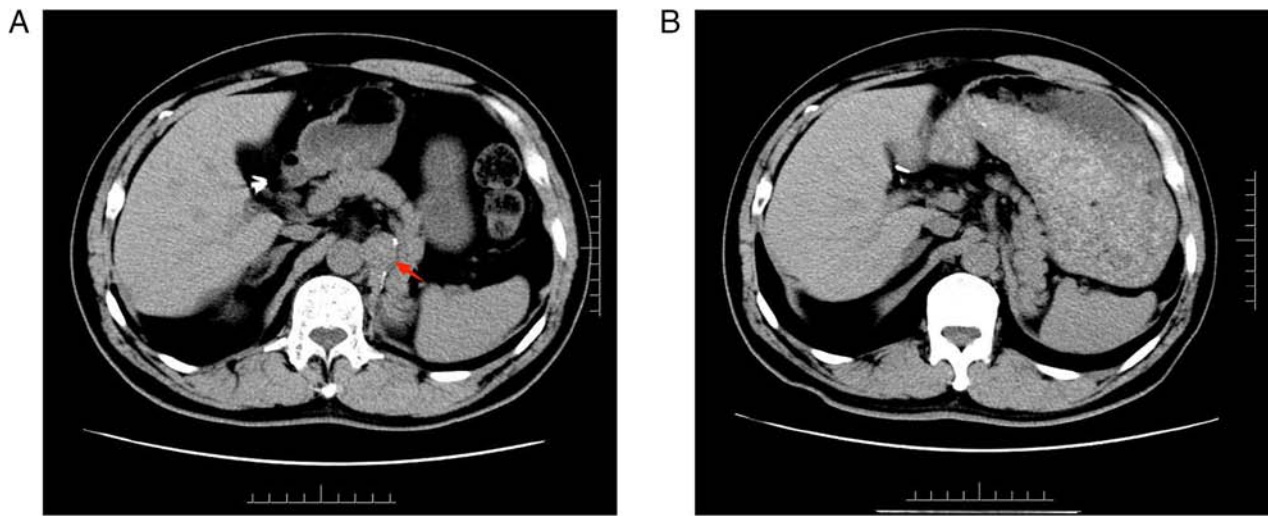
Abdominal CT. (A) Abdominal CT in November 2021 revealed para-aortic lymph node carcinoma metastasis (red arrow). (B) Postoperative review via enhanced abdominal CT in February 2022 indicated complete resection of retroperitoneal metastases. CT, computed tomography.
